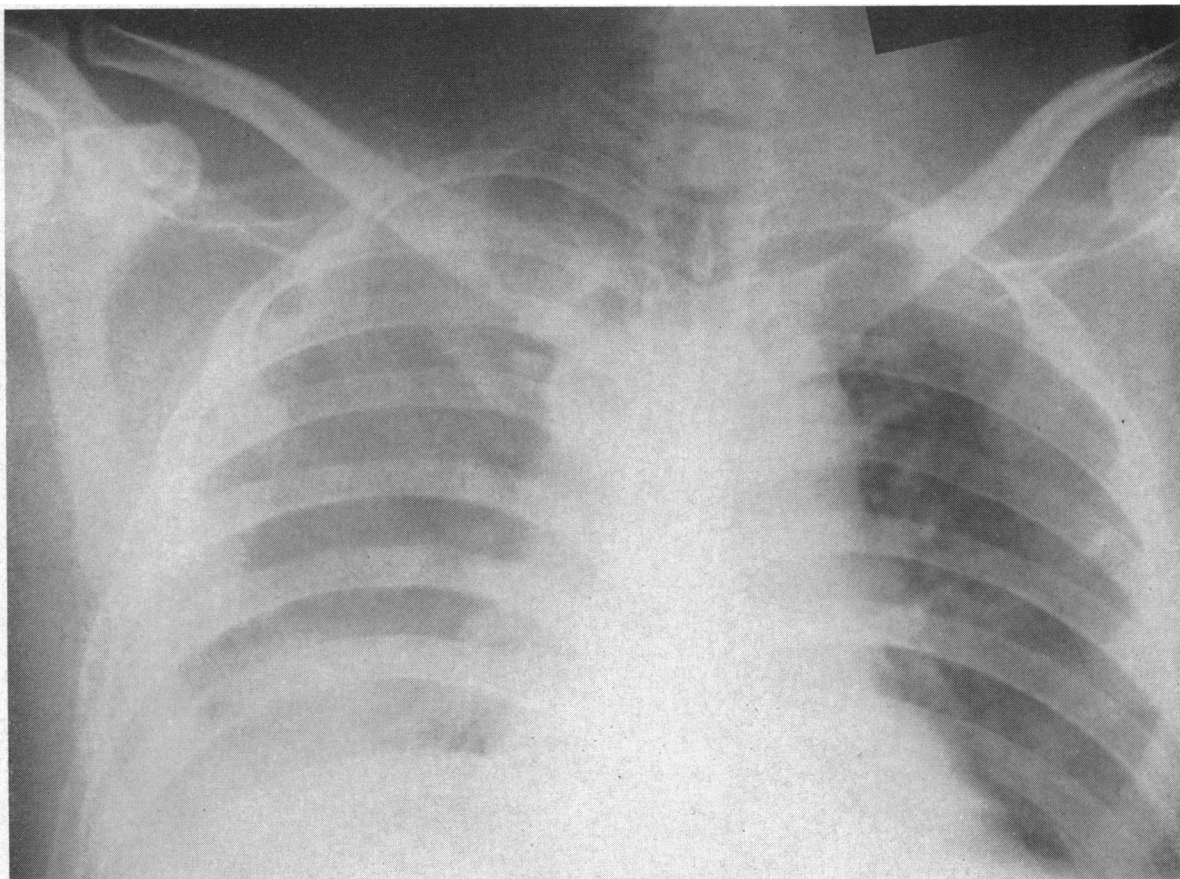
X-ray film of chest on admission showing diffuse increased density in both lung fields but greater on the right.
